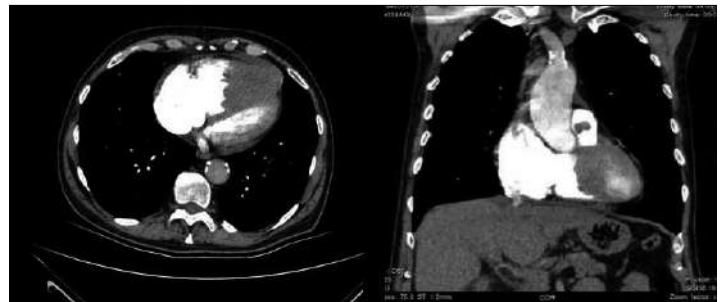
Contrast computed tomography pulmonary angiogram showing a dilated right ventricle and a filling defect, both in the right ventricle and in the pulmonary artery.
